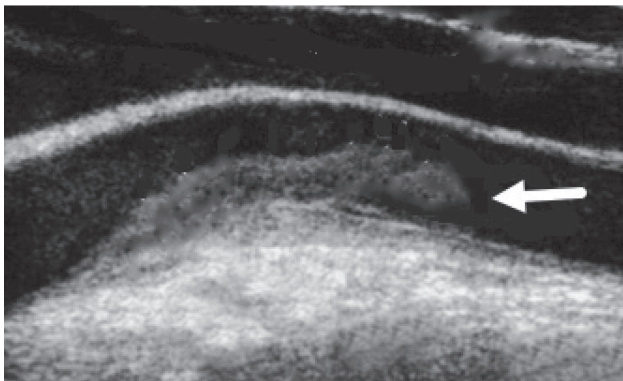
Ultrasound scan of the internal carotid artery. Arrow indicates the free-floating part of the thrombus.
